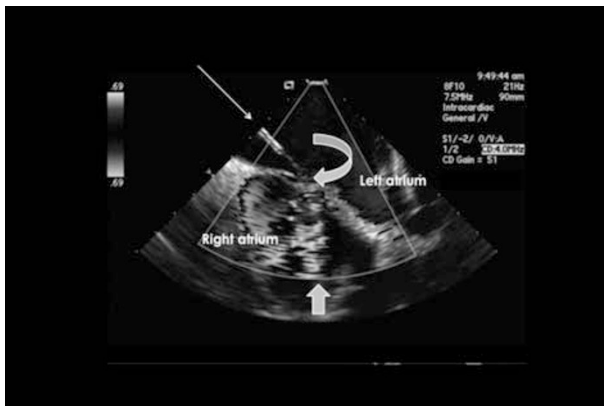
Intra-operative trans-oesophageal echocardiography showing percutaneous femoral catheter (thin arrow) in the right atrium and the closure of the defect (curved arrow). The thick arrow indicates flow towards the defect.
